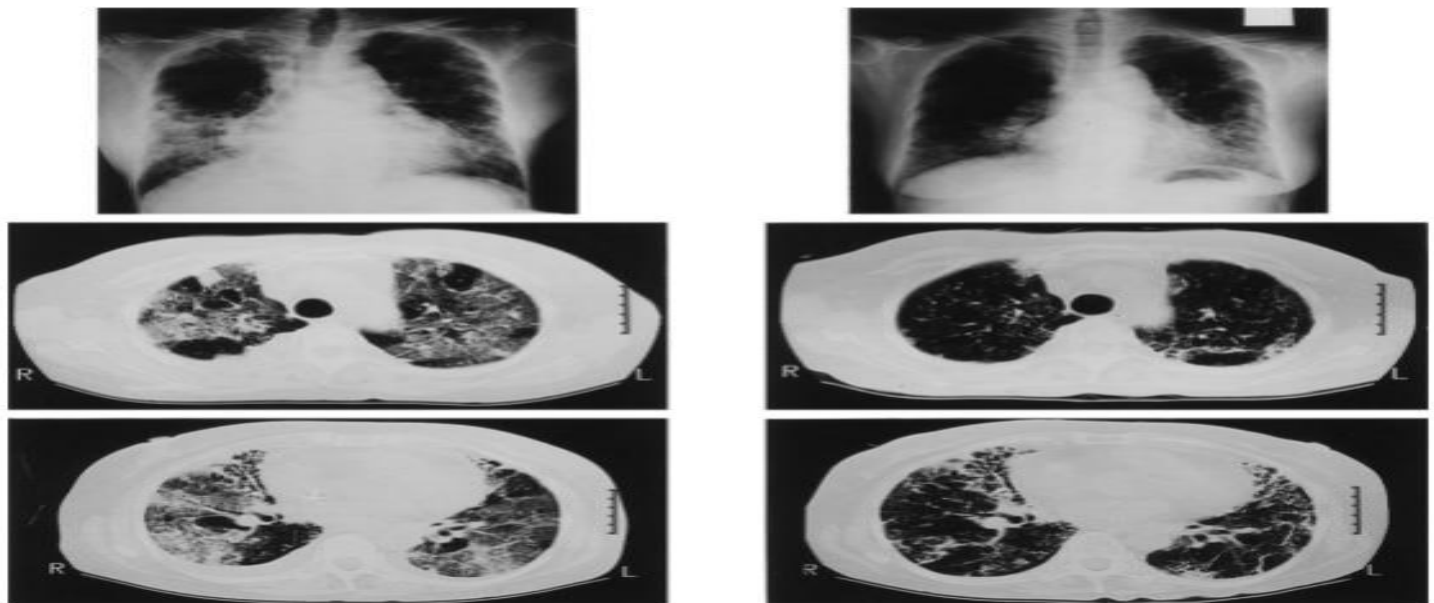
Chest X-ray and CT before (left) and after (right) the initiation of combined CyA + prednisolone therapy. (Top left) Chest X-ray showing diffuse reticular infiltrates in both lung fields. (Lower two panels, left) Chest CT demonstrating bilateral patchy areas of ground-glass appearance in the outer and inner zones. Note the lack of honeycombing. (Top right) Chest X-ray showing remarkable improvement (compare with left side). (Lower two panels, right) The ground-glass appearance disappeared on chest CT 3 months after initiating the combination treatment. Note the presence of slight irregular pleural thickening but no obvious honeycombing.
